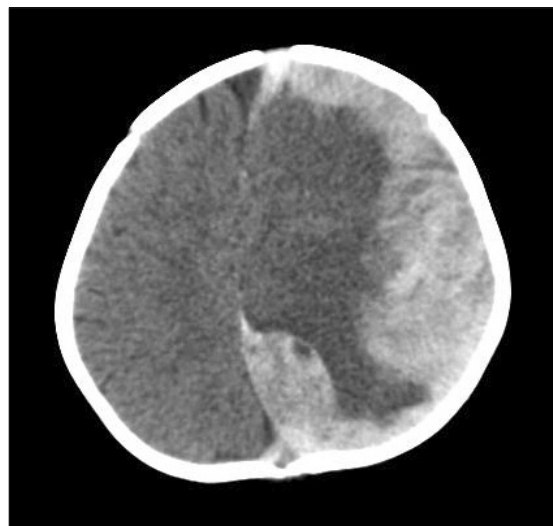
Head computed tomographic scan shows subdural hematoma along the left lateral cerebral convexity with a midline shift and the compression of underlying brain parenchyma.
